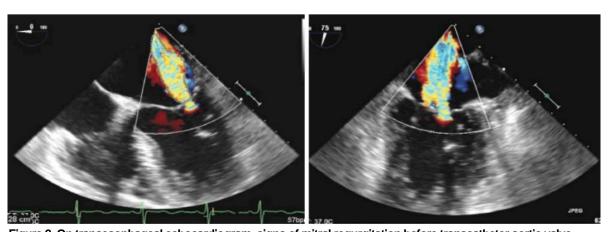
On transesophageal echocardiogram, signs of mitral regurgitation before transcatheter aortic valve implantation (TAVI) are seen.
